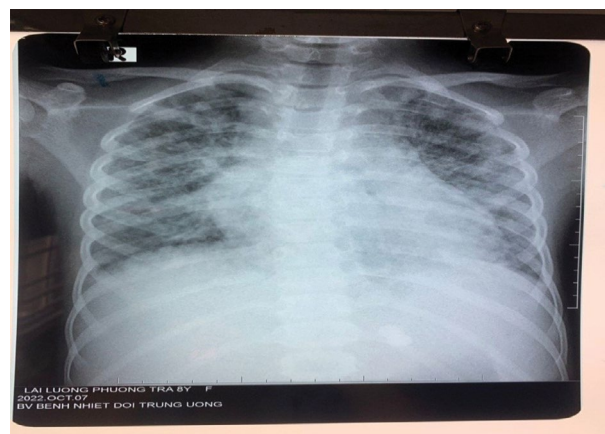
X-ray of the lungs (Oct 7.2022)
